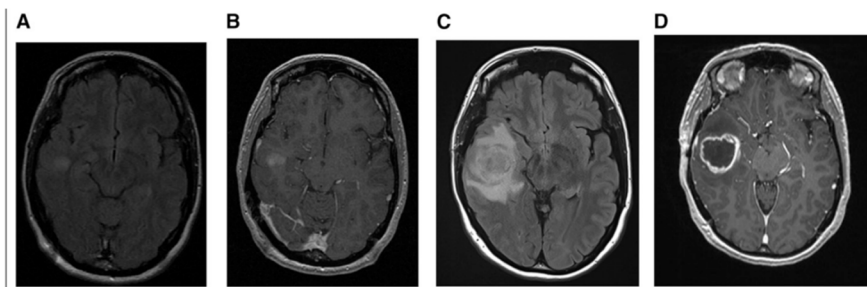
MRI of a GBM during the time. The images show the rapid evolution of the tumour in only 20 days.
